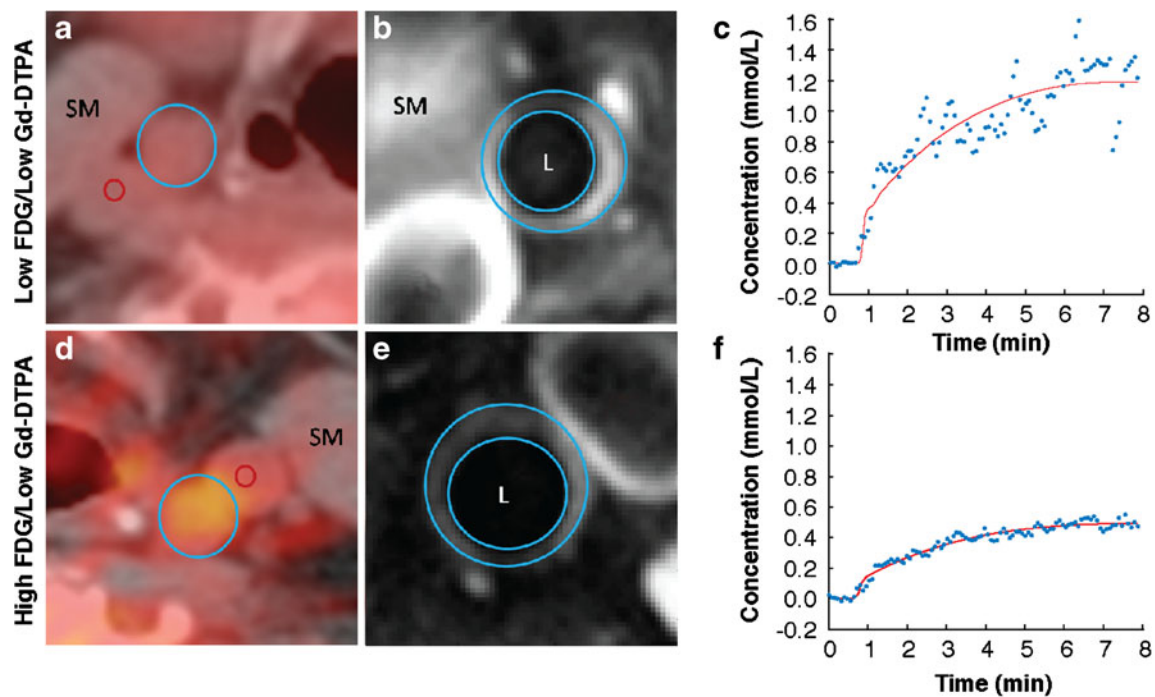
^{18}F -FDG PET/CT images and Gd-DTPA uptake data by DCE-MRI from representative patients showing the relationship between Gd-DTPA uptake and ^{18}F -FDG uptake. a–c Patient with low arterial FDG uptake by PET/CT but high Gd-DTPA uptake by DCE-MRI. d–f Patient with high arterial FDG uptake by PET/CT but low Gd-DTPA uptake by
